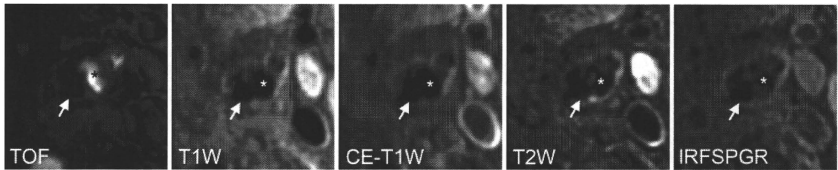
A representative case of calcified plaque from a female patient. Hypointensity area seen on all the images (arrows) indicates calcified plaque. *Lumen. TOF indicates time of flight; T1W, T1-weighted; CE-T1W, contrast-enhanced T1-weighted; IRFSPGR, inversion recovery fast spoiled gradient recalled.
